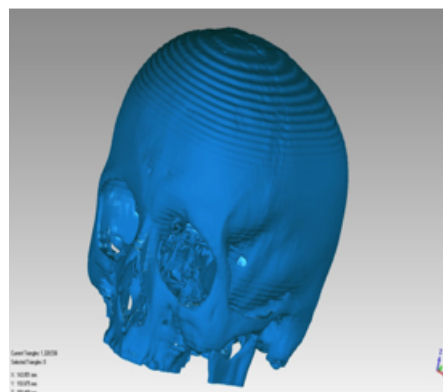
3D computer reconstruction of the skull using data from CT examinations.
